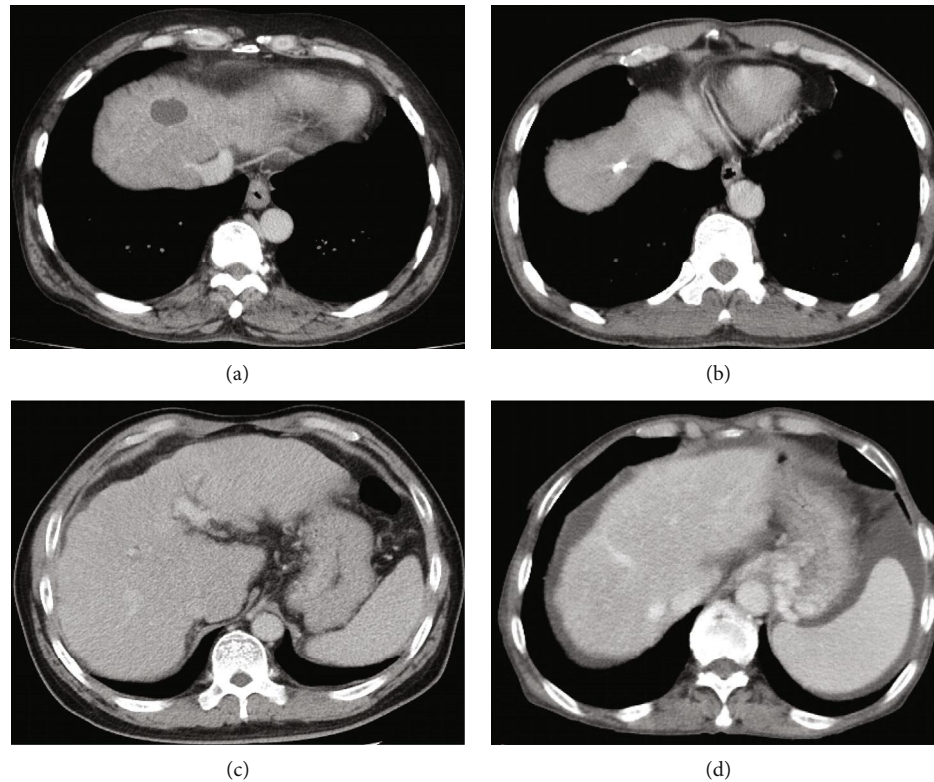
Pitfalls in diagnosis of GEVs on contrast-enhanced CT. (a) Esophageal wall became stiff after repeated endoscopic treatments. (b) Small EVs were observed on contrast-enhanced CT, but missed on endoscopy. (c) GVVs could not be evaluated as gastric cavity was not fully expanded. (d) GVVs appeared as irregular vascular shadows, where the maximum diameter of varices was hard to be measured. CT: computed tomography; GEVs: gastroesophageal varices; EVs: esophageal varices; GVVs: gastric varices.
